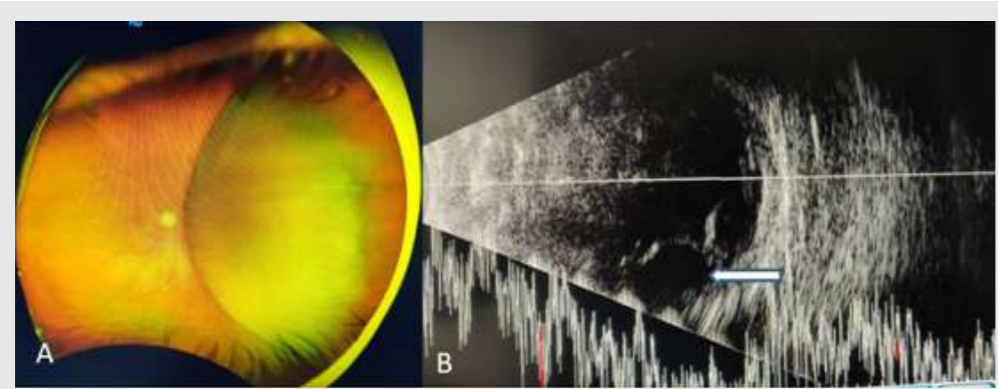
A; Shows temporal serous choroidal detachment in the right eye. B; Shows ultrasonic appearance of serous choroidal detachment (white arrow)
